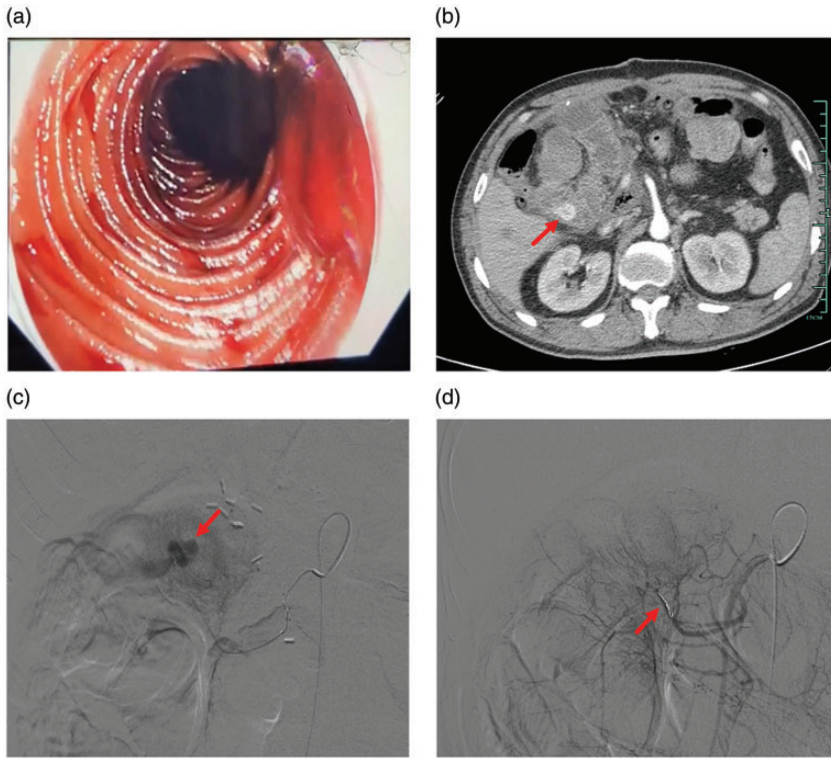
(a) The afferent loop under endoscopy. (b) CECT scan of the abdomen on POD10. Red arrow: contrast agent. (c) and (d) Images obtained during the urgent DSA. (c) Before embolization. Red arrow: contrast agent. (d) After embolization. Red arrow: coils. CECT, contrast-enhanced computed tomography; POD, postoperative day; DSA, digital subtraction angiography.
